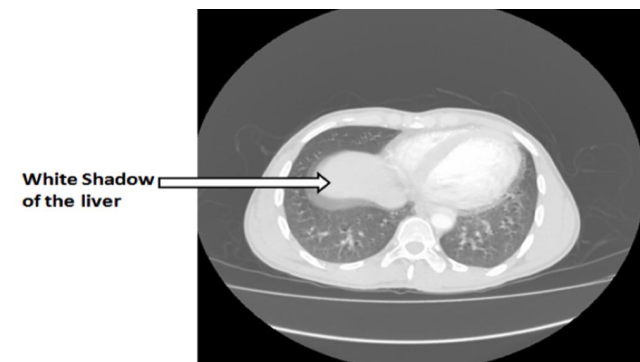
CT angiography of Toshiba Aquilion™ 64 slice, shows liver dome in an axial CT abdomen.
